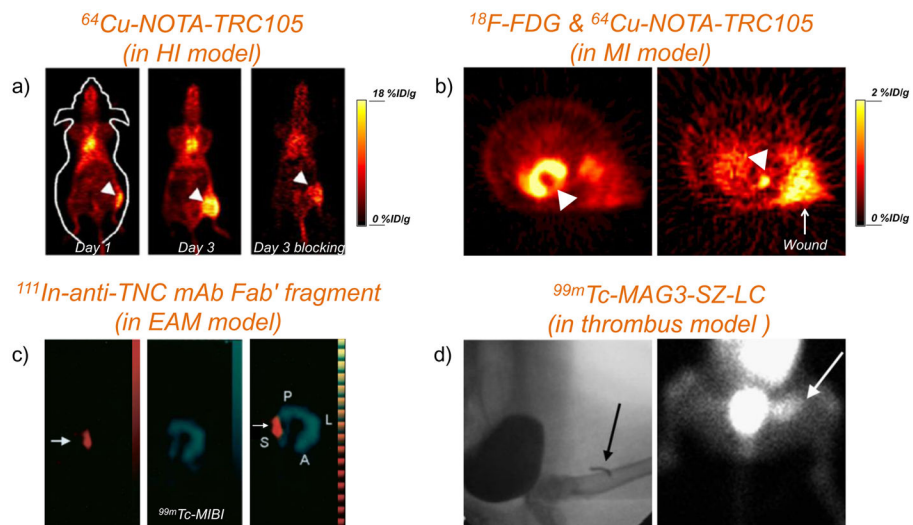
PET or SPECT imaging of vascular targets in cardiovascular disease models
